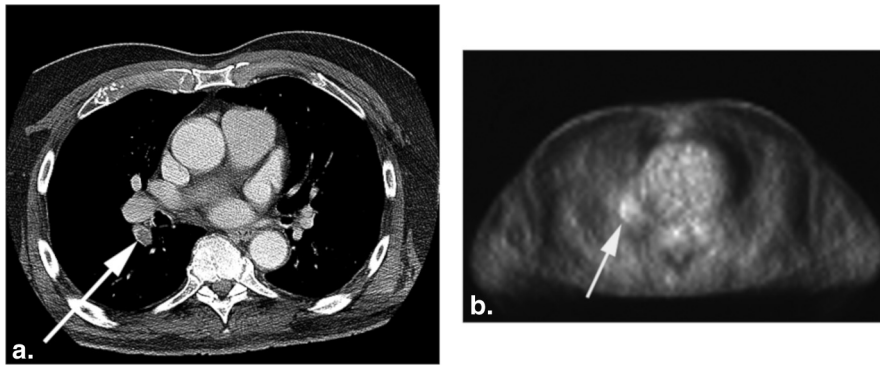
Example of pulmonary artery hypermetabolism. A 75-year-old woman with history of melanoma. (a) Incidental right lower lobe segmental pulmonary embolism seen on computed tomography. (b) The associated PET demonstrates mild focal pulmonary arterial hypermetabolism, with an SUV_{max} of 2.0. PET, positron emission tomography; SUV, standardized uptake value.
